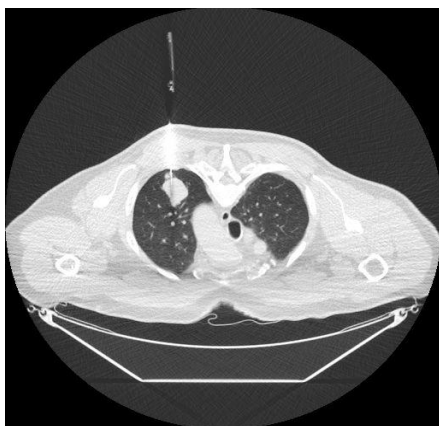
Fine-needle aspiration biopsy under computed tomography guidance in prone position (03/2019).
